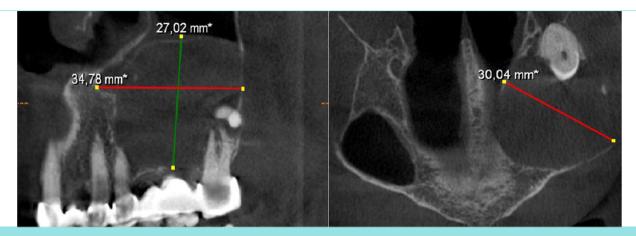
CBCT images of the lesion. CBCT: Cone beam computed tomography
